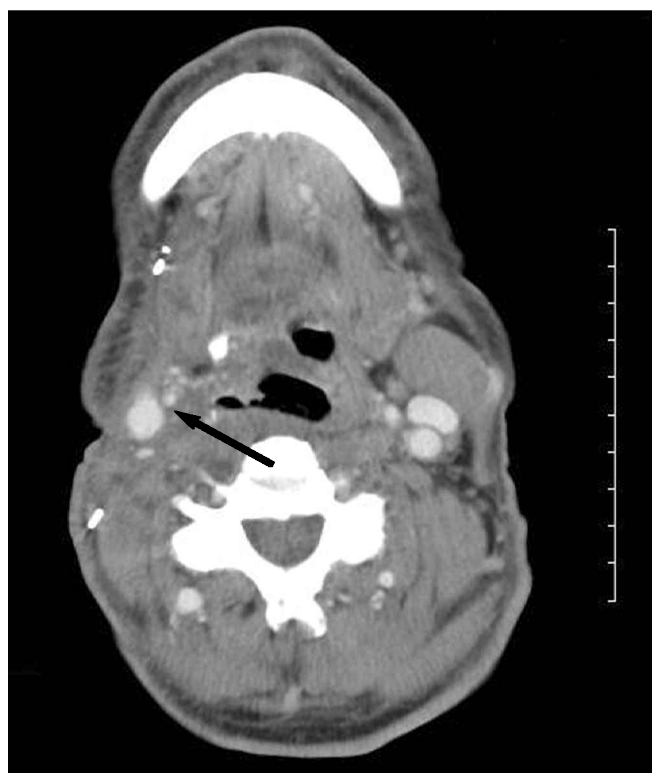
CT scan at the level of the carotid body, showing signs of malignant invasion into the right vagus nerve and right carotid body (arrow).
